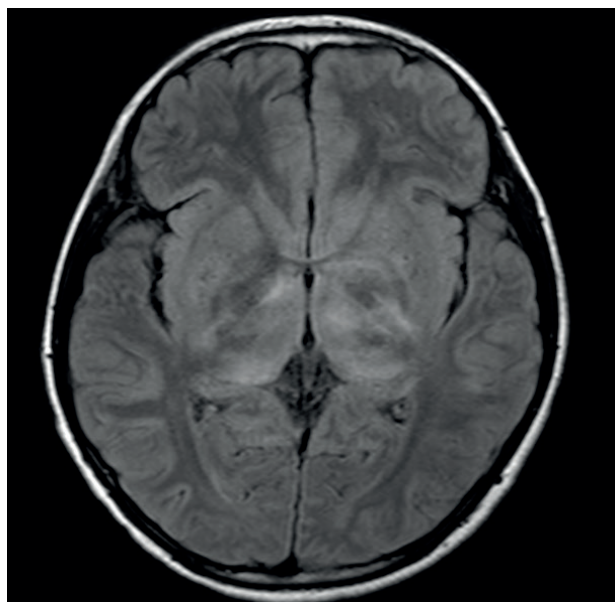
Axial MRI in FLAIR sequence shows abnormal hyperintense signal within bilateral basal ganglia and internal capsule.
